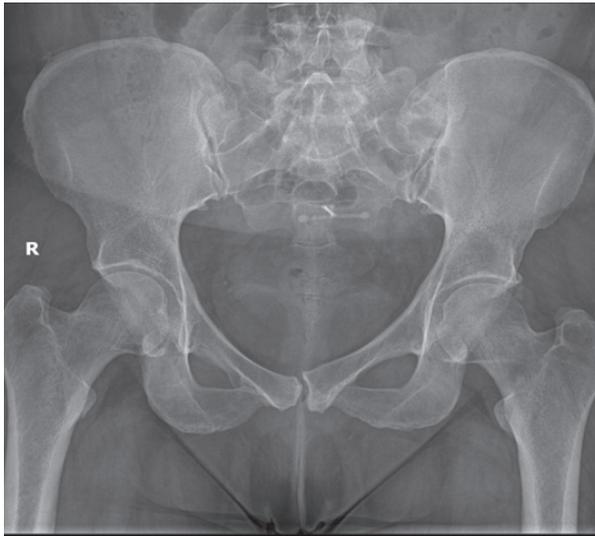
Radiograph and MRI of the lumbar spine and sacroiliac region, presenting degenerative changes in the joint
